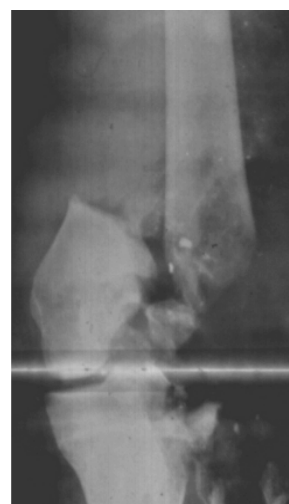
Case 1 - Radiograph of the total destroyed knee joint.
